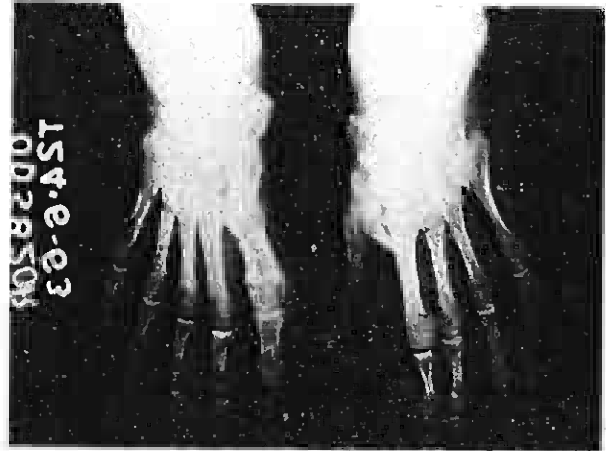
The X-rays of the feet of Case I. Note the partial absence and abnormality of the left 1st metatarsal. There is also a partial duplication of this metatarsal.
